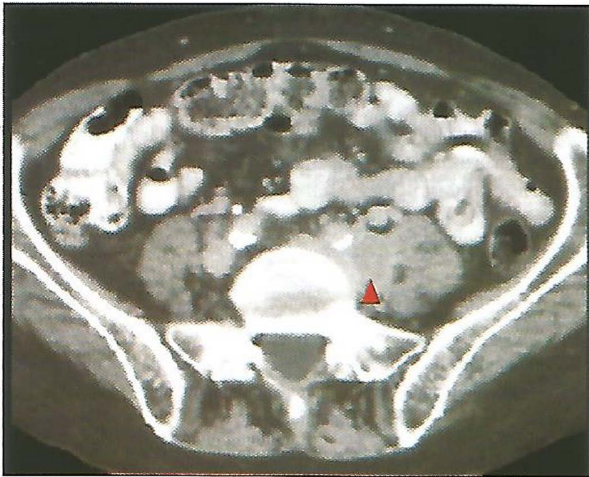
Retroperitoneal lymph nodes. CT-scan.
